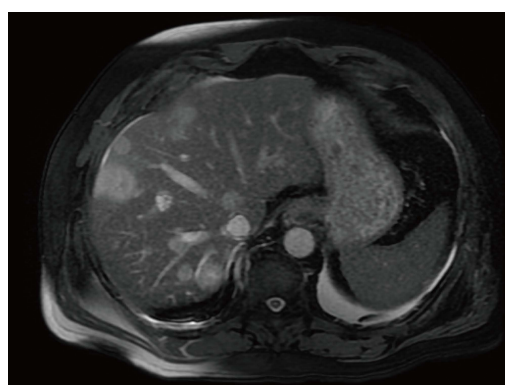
Magnetic resonance imaging showing multiple metastatic liver lesions.
